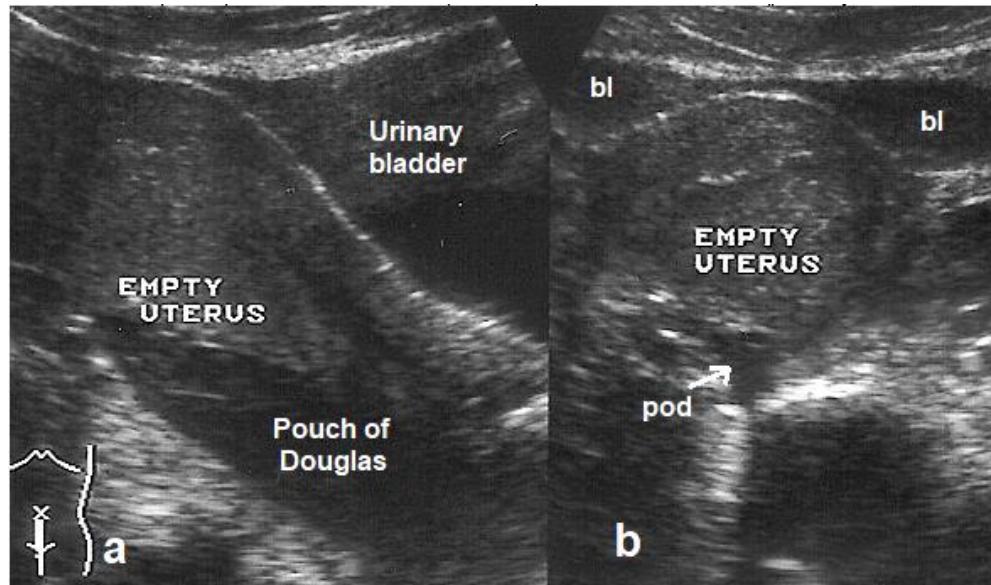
Sonogram of a non-gravid uterus with mild reactive fluid in the pouch of Douglas (pod) due to P.I.D. bl = urinary bladder. B. longitudinal view. b. Transverse view.
